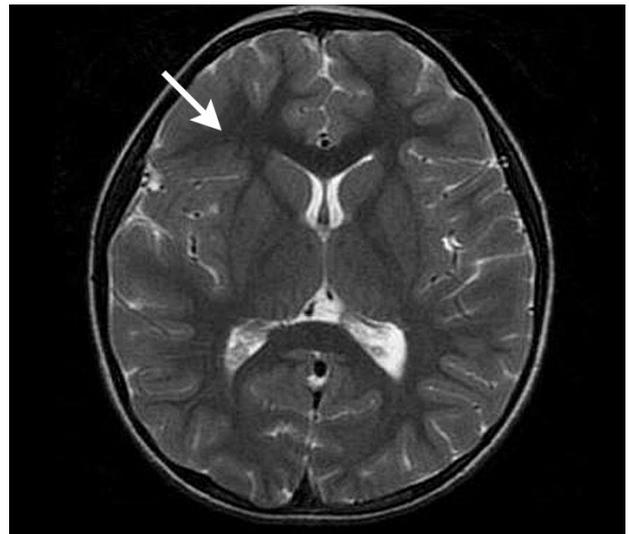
Brain T2W MRI demonstrating a right orbitofrontal lobe cortical dysplasia (indicated by the arrow).
